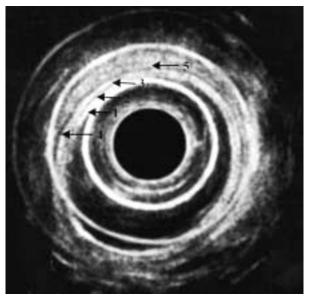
Endoscopic ultrasonography (EUS, 20 MHz) showing the five-layered structure of the normal esophageal wall. 1-2) mucosa (hyper-echoic and hypo-echoic layers); 3) submucosa (hyper-echoic layer); 4) muscularis propria (hypo-echoic layer); 5) adventitia (hyper-echoic layer).
